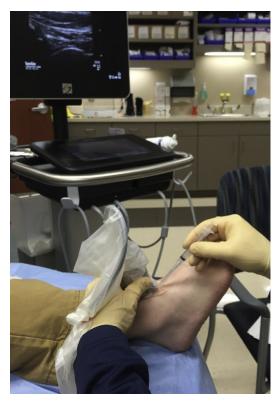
Ultrasound transducer placement and needle approach for ankle joint injection, in plane with ankle, needle approaching in plane with transducer. Left, proximal; right, distal.
